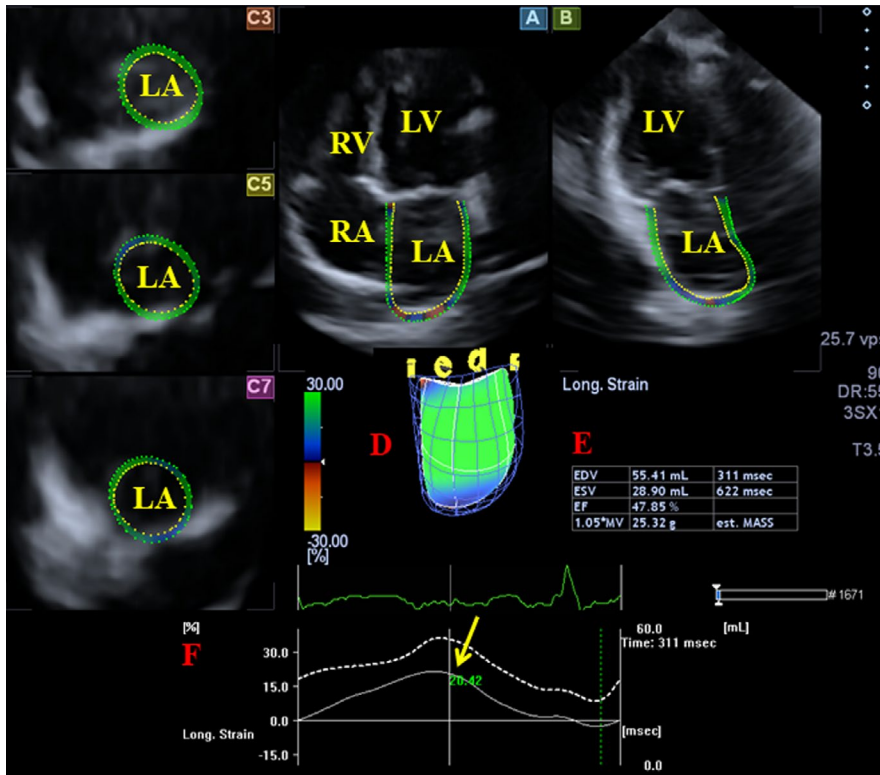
Three-dimensional (3D) speckle-tracking echocardiographic evaluation of the left atrium (LA) is displayed in a patient with lipedema. Apical four-chamber (A) and two-chamber (B) views, short-axis views at basal (C3), midatrial (C5), and superior LA level (C7) are shown together with a 3D cast of the LA (D) and calculated volumetric LA data (E). Time—global LA volume change (dashed line) and time—global LA longitudinal strain curves (white line) are also demonstrated (F). The yellow arrow represents global peak LA-LS featuring LA reservoir function. EDV = end-diastolic volume; EF = ejection fraction; ESV = end-systolic volume; LA = left atrium; LV = left ventricle; RA = right atrium; RV = right ventricle
